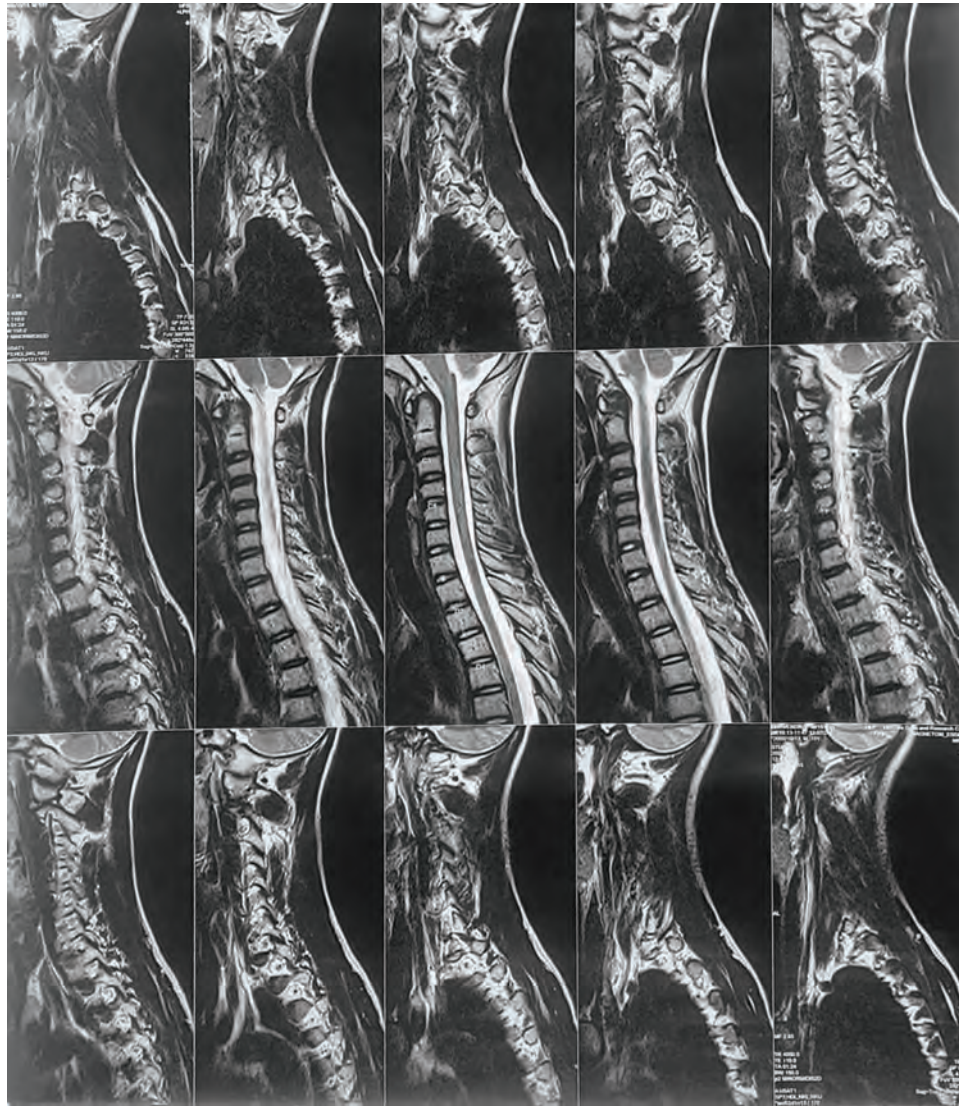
T2-weighted MRI of spine (sagittal section)
